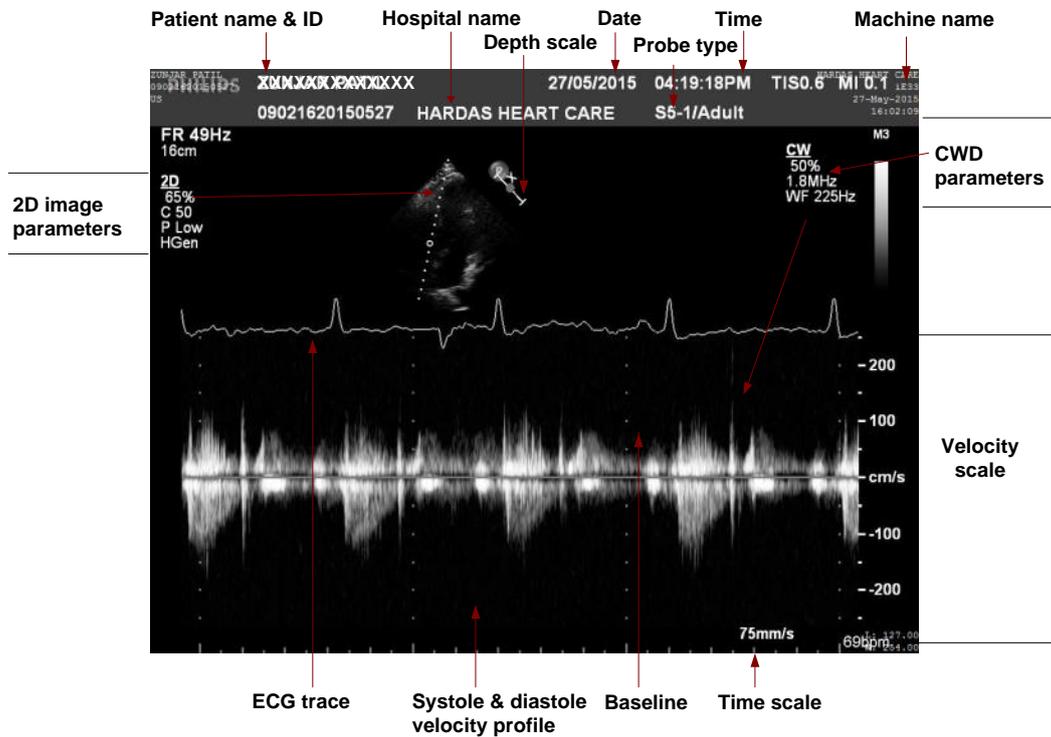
Echocardiogram (2D and CWD) in apical five-chamber view (machine: Philips 'iE33') recorded from the subject SNH-ZP, along with description of different fields in the display.
